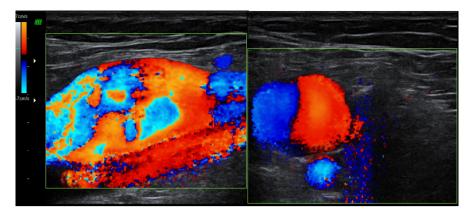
Axial and sagittal color duplex ultrasonographic images of left popliteal cavity after calf veins squeezing demonestrates popliteal aneurysm anterior to popliteal artery.
